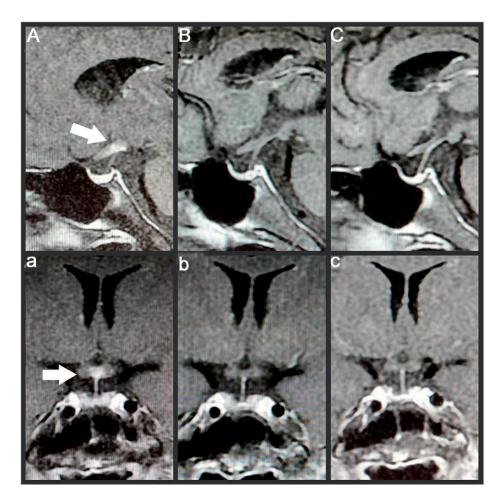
MRI imaging pre- and post-treatment. (A,a) A hypothalamic mass was detected before treatment. The pituitary was slightly flattened and the PPBS was gone. (B,b) An MRI re-scan showed regression of the mass post-therapy. (C,c) No signs of relapse were observed.
